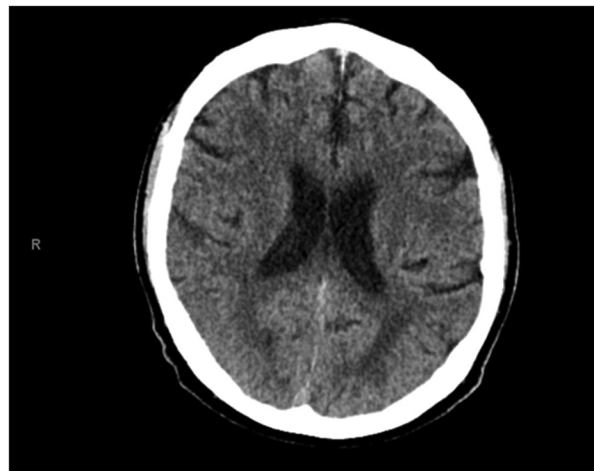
Non-contrast computed tomography of the head during the initial presentation, where there was no evidence of an acute hemorrhage, ischemia, or other processes.
